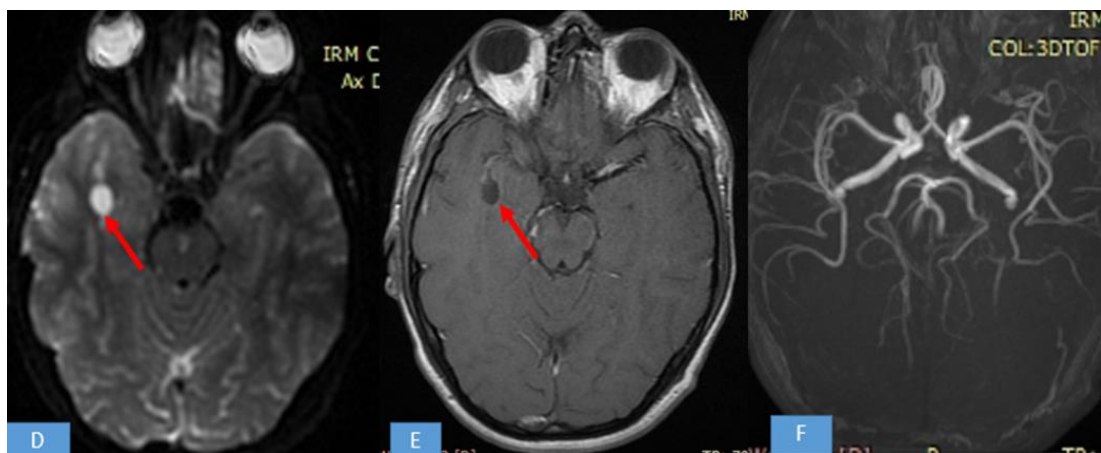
Brain MRI: Diffusion Axial (D), T1 axial after Gadolinium injection (E) and arterial angiography reconstruction (F) sequences. This lesion (red arrows) is in diffusion hypersignal, not enhanced by the contrast product. There is no abnormality in the arterial angiographic sequences
